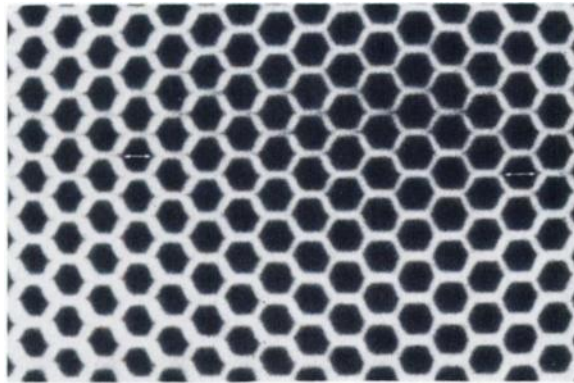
Shows enlarged radiograph of hexagonal holes. Note tiny spaces at opposite angles of each hole (see arrows), corresponding to polarity of collimator.
